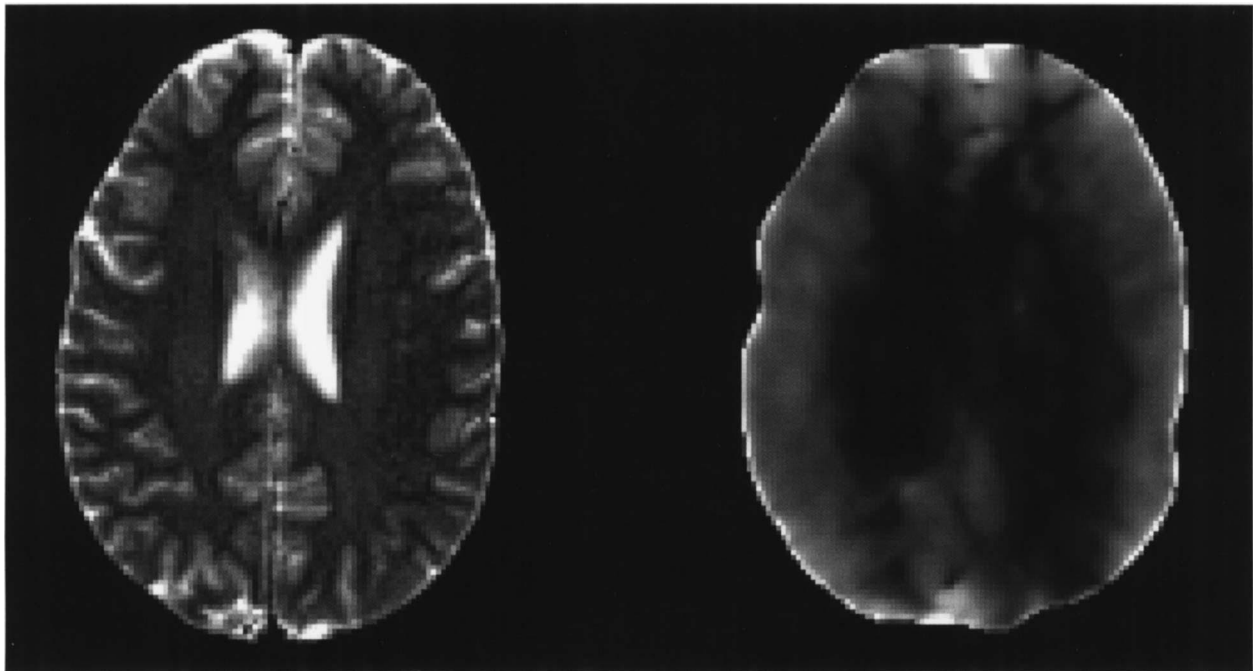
(Left): T2-weighted spin-echo cerebral image of a volunteer. (Right): Local frequency elastogram (inverse wave speed), showing relative differences between gray and white matter. Shear waves were generated in the brain at 100 Hz by applying lateral motion to a thermoplastic bite bar held in the teeth of the volunteer. One of the wave images from this data set is shown in Fig. 3.
